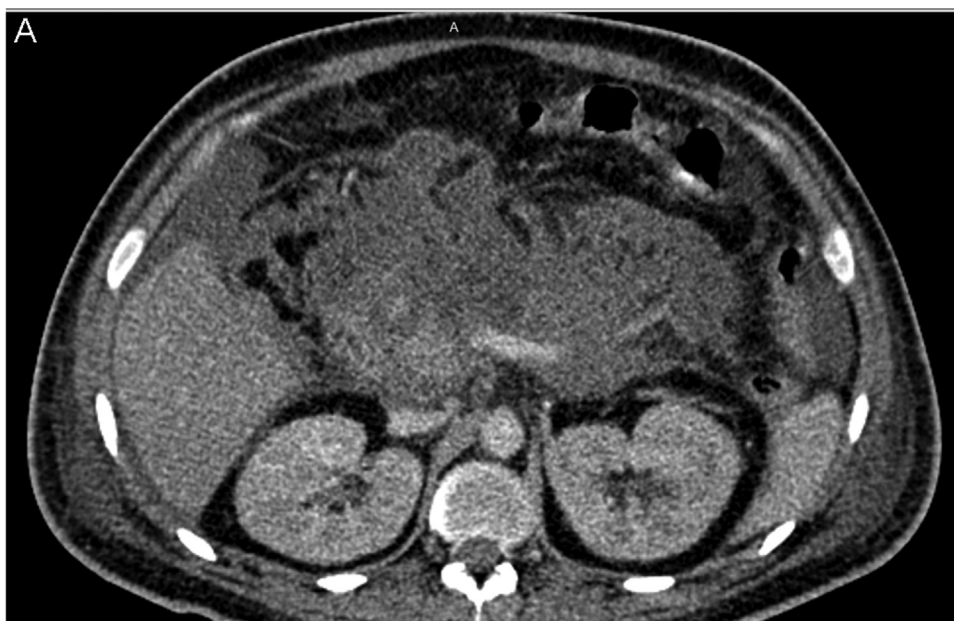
Computer tomography (CT) scan of pancreas. (A) Representative image of severe pancreatic necrosis and excessive peripancreatic fluid collection.
